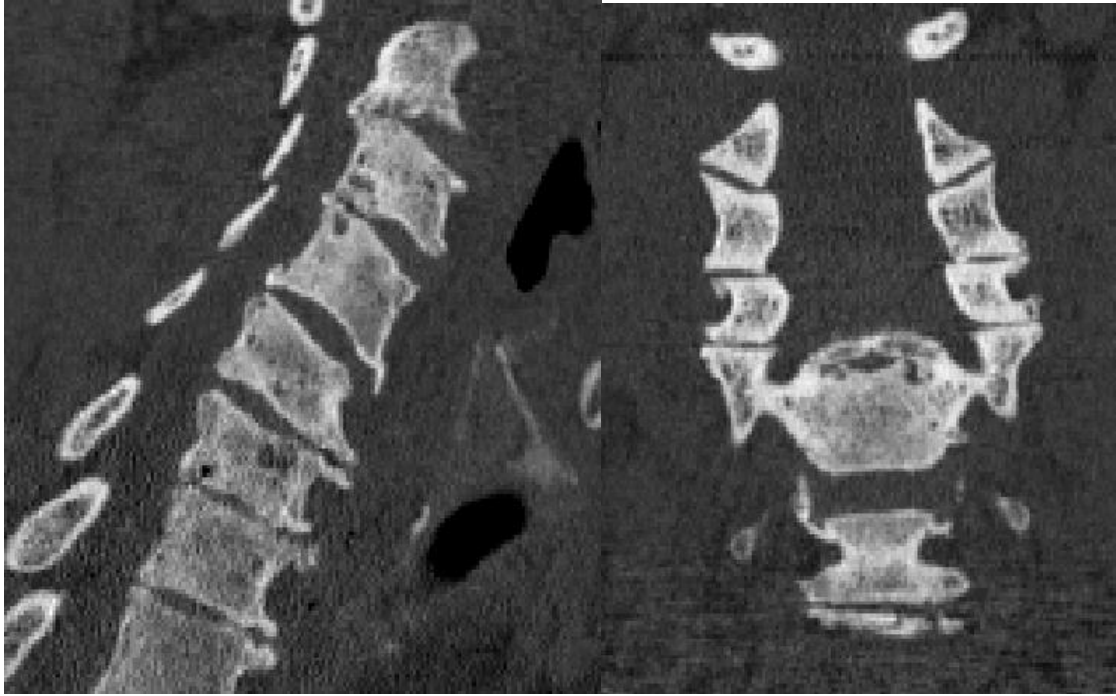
Osteophytes of the CT images (Taken from the CT of the patient).*
